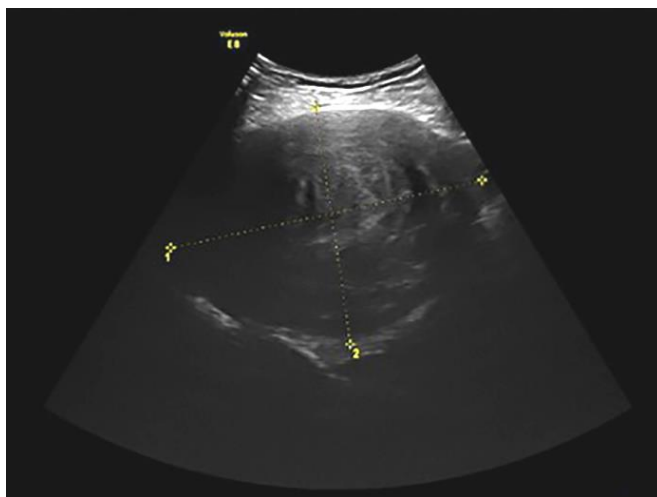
Ultrasound image: longitudinal view of the lower abdomen showing a mass with echogenic characteristics of uterine fibroid in the left adnexal area
